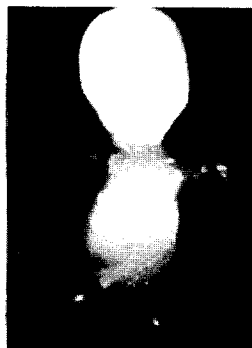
(Case I) Postnatal radiograph confirms the prenatal findings. (micromelia with bowed femurs, enlarged head, and flattened vertebral bodies; H-shape)
